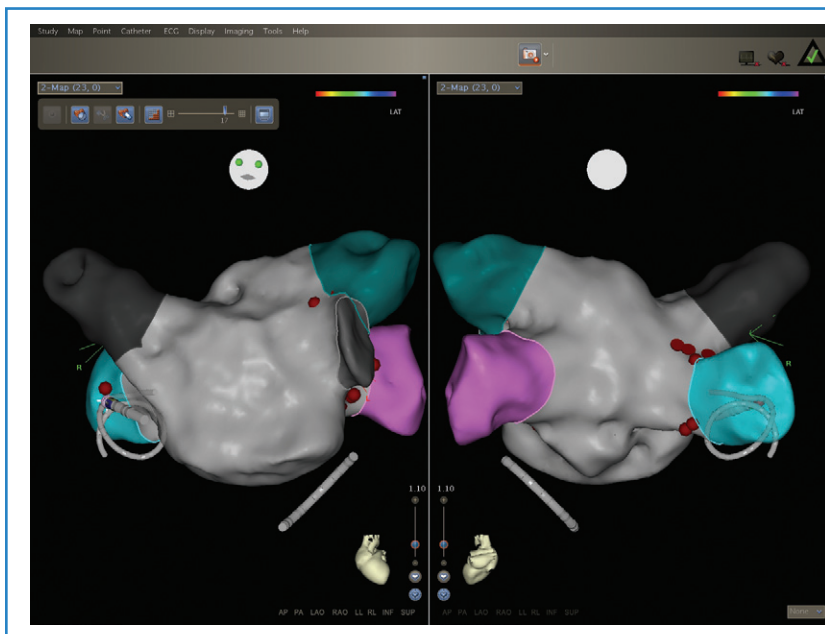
CARTO SOUND (Biosense Webster) integrating CARTO acquired geometry and real-time imaging with intracardiac echocardiography.
